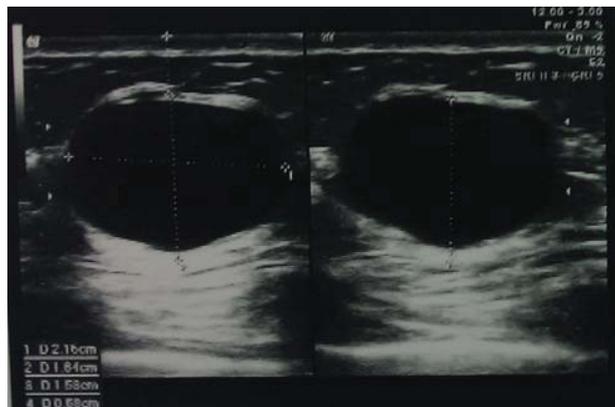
Ultrasonography of the breast mass.
